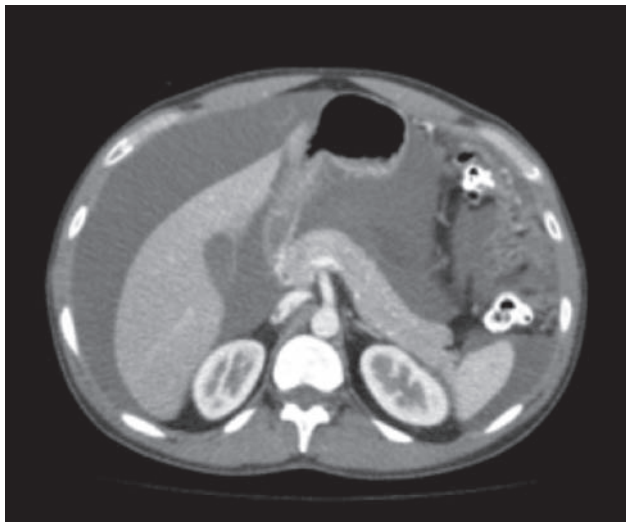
Representative pre-operative CT scan images demonstrating diffuse abdominal ascites, without parenchymal involvement or lymphadenopathy.
